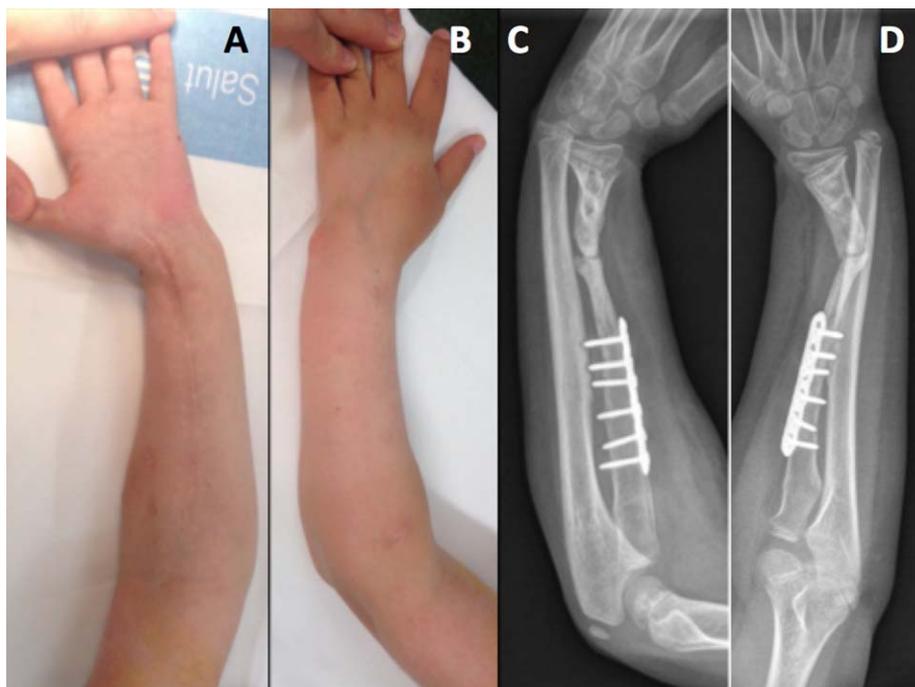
Preoperative radiographs and clinical image of complex radial nonunion and residual dorsal-radial angulation of the radius
